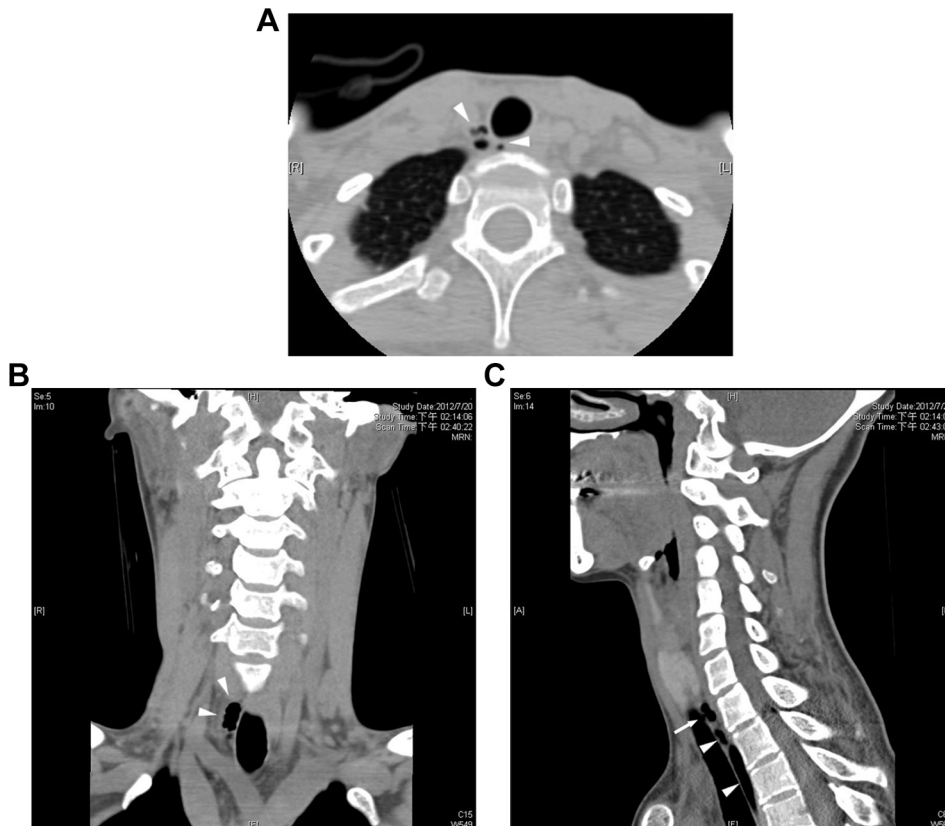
Neck non-contrast-enhanced CT scan demonstrated free air (arrowheads) alongside the upper trachea. The prevertebral soft tissue was not swelling. (A) Transverse view; (B) coronal view; (C) sagittal view.
